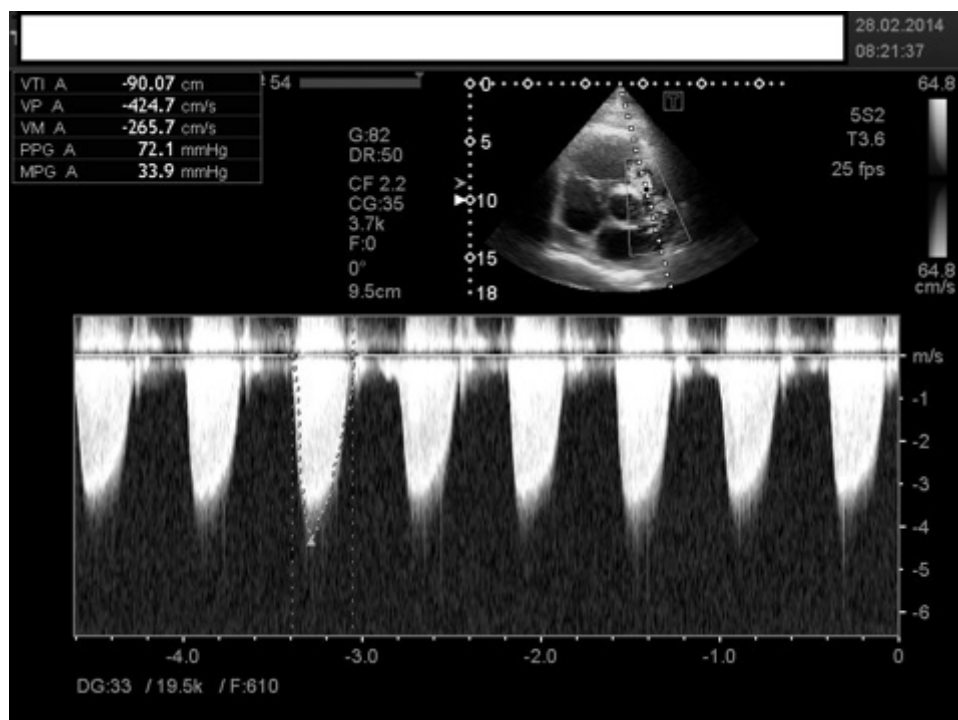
Echocardiography: tricuspid regurgitation
